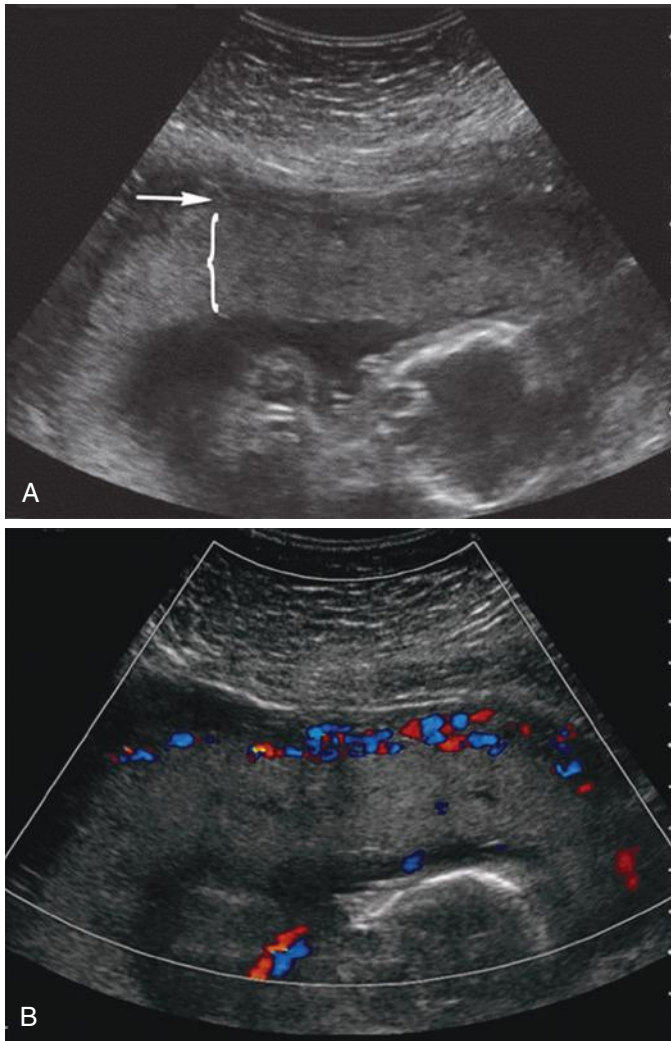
Second-trimester placenta. A, The placenta is isoechoic with its adjacent myometrium, its thickness is marked by the bracket, and an arrow points to the retroplacental space. B, With color Doppler, vessels are seen spanning the retroplacental space. (Courtesy of Adriana Male, RDMS, Parkland Health and Hospital Systems, Dallas, Texas.)
